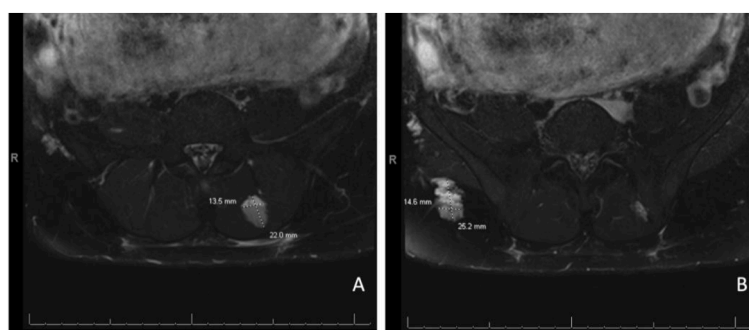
Magnetic resonance imaging without contrast of lumbar spine showing lesions indicating venous malformations (A) at L4-L5 and (B) within the subcutaneous fat of the right buttock.
